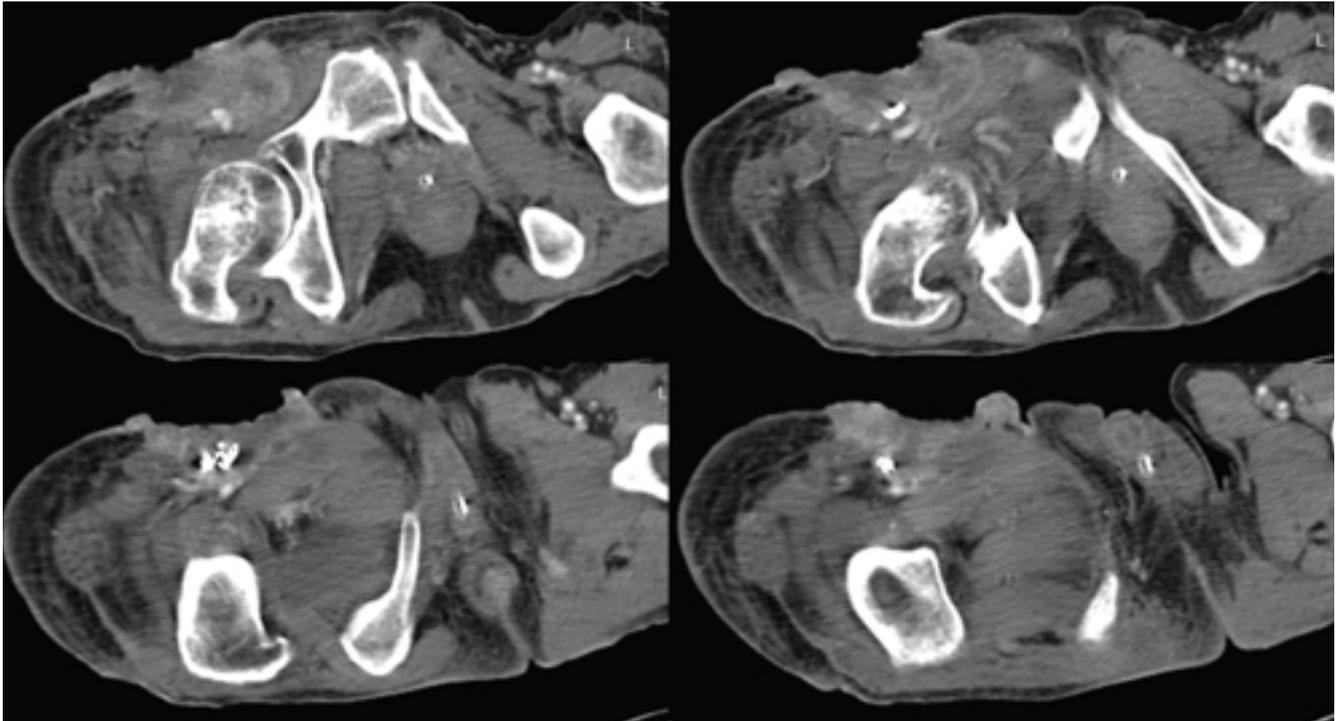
On follow-up contrast-enhanced CT at 1 week after embolization, pseudoaneurysm cannot be found. A large, inhomogeneously enhancing mass lesion involves the right inguinal region, along with evidence adjacent arterial invasion and skin ulceration.
